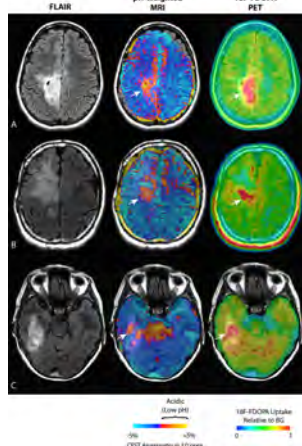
MRI and PET data for three GBM patients. pH-weighted CEST MRI appears to identify similar lesions as <sup>18</sup>F-FDOPA PET.
